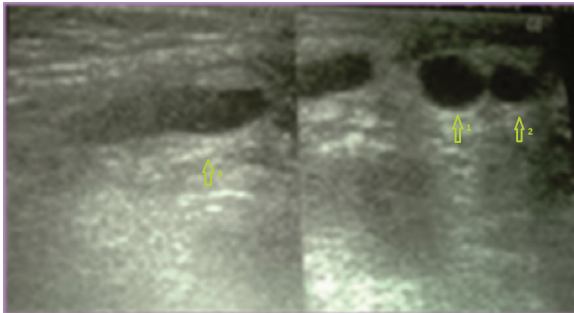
Ultrasonographic image demonstrating three lesions in the upper right quadrant of the right hemi-scrotum measuring 5 mm (arrow 1), 7 mm (arrow 2) and 20 mm (arrow 3) in their greatest dimensions.
